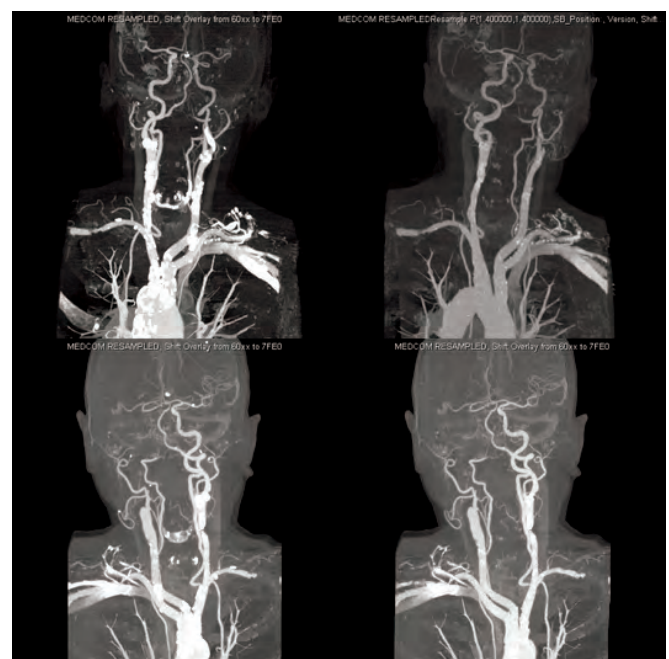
CT ANGIO 3D reconstruction: Evolution of Right Internal Carotid Artery Stenosis.
